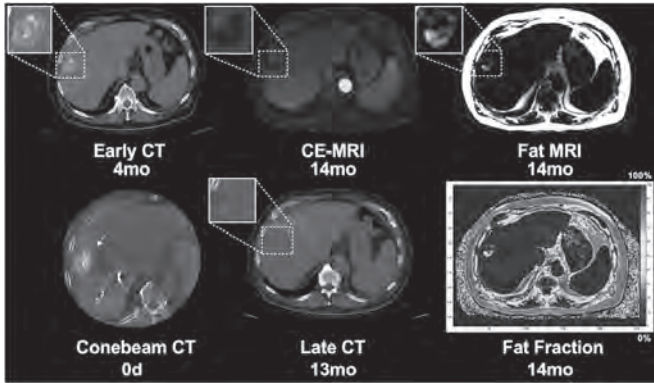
Images from a 73-year-old man with cirrhosis and HCC tumor in segment VIII (arrow) treated with TACE. Conebeam CT confirmed lipiodol delivery on day of treatment (lower left). CT identified lipiodol accumulation in the tumor and surrounding hepatic parenchyma 4mo after treatment. Late CT 13mo after treatment demonstrated markedly less attenuation in the treated segment VIII tumor. Follow-up MRI 1mo later showed persistent necrosis and anterior focal nodular enhancement on contrast-enhanced (CE) MRI that correlated with signal void in the fat image and the calculated fat fraction map.
